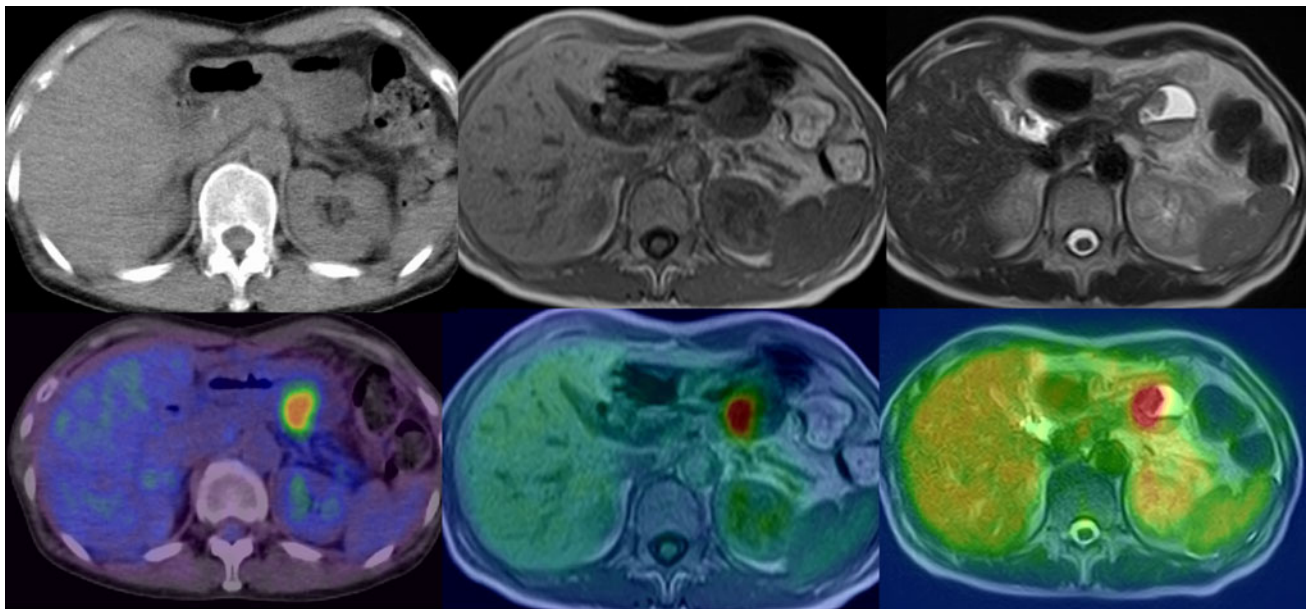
Low-dose CT showed cystic lesion of pancreas tail (*left upper*). FDG-positive lesion was noted in the cystic tumor by PET/CT (*left lower*). Mural nodule was noted on MRI T1WI (*center upper*). Accordant FDG uptake with mural nodule was noted on PET/MRI-T1
